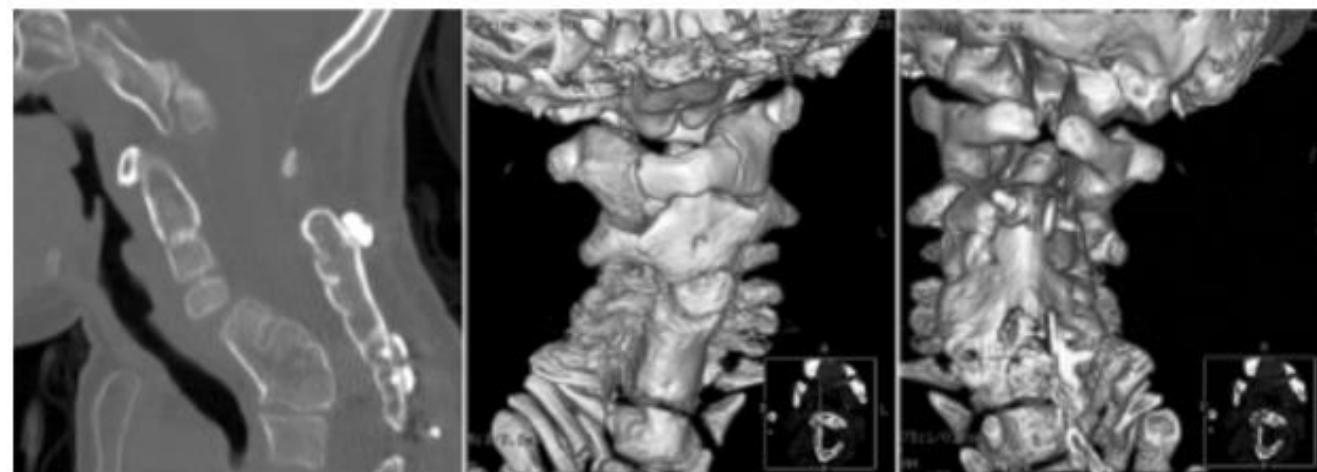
Case 1. Postoperative sagittal CT reconstruction (left) and three-dimensional models (center and right) demonstrating solid anterior and posterior fusion constructs. Right: Note the posterior wire and titanium disc construct.
